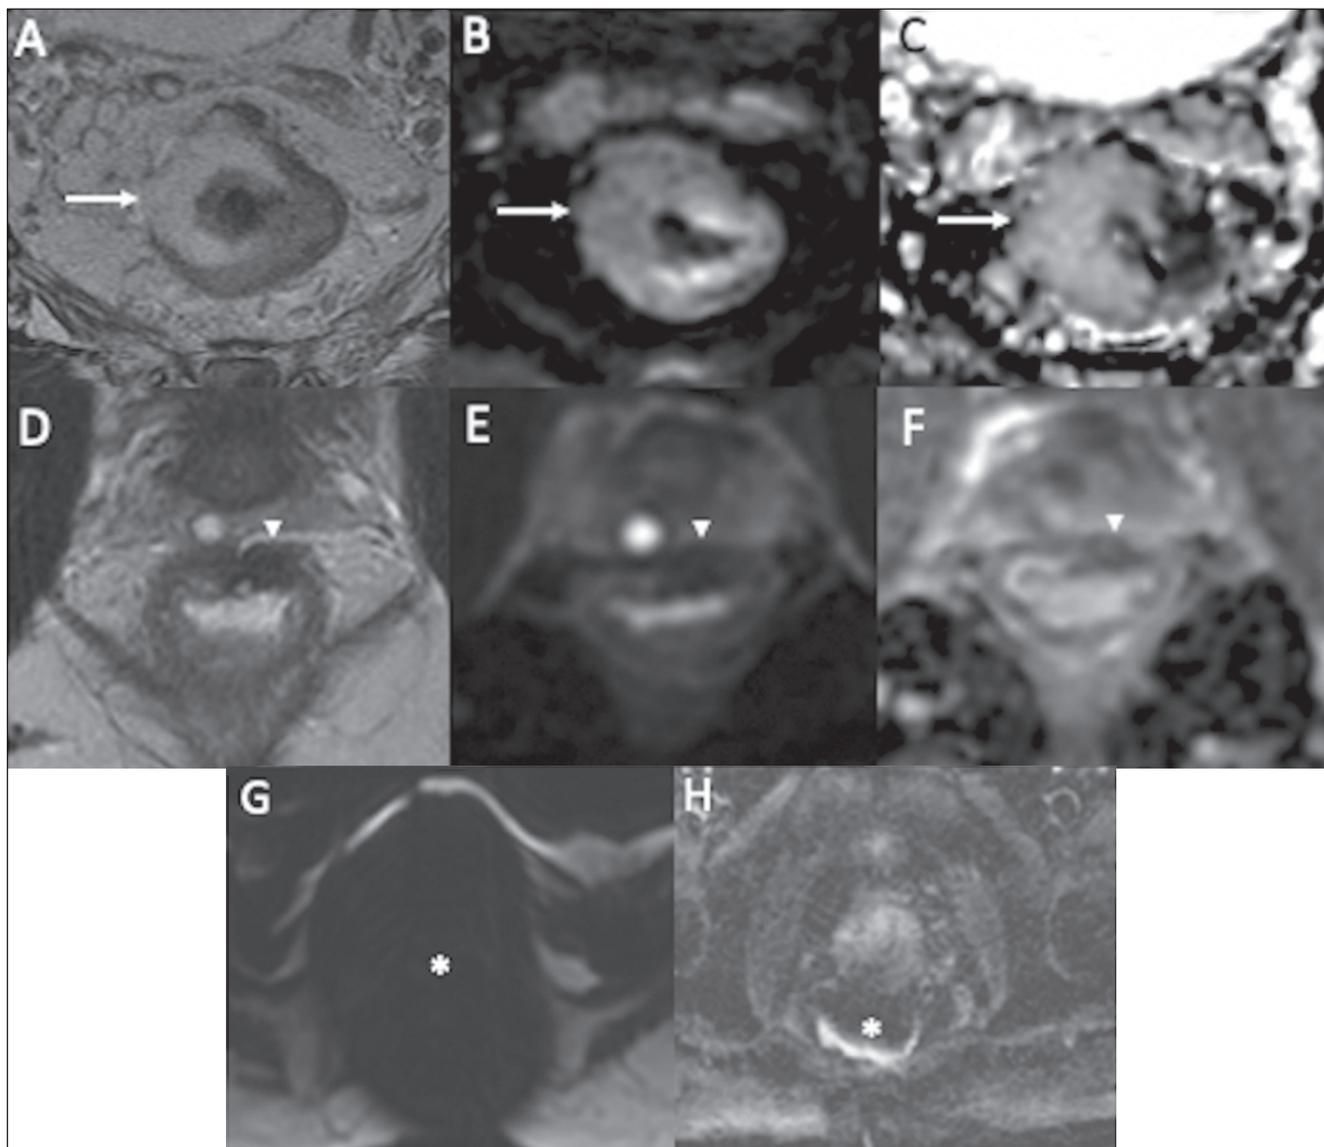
Examples of DWI artifacts. A–C: A T2 shine-through artifact (arrows) in a patient with a mucinous tumor showing high signal intensity on T2WI (A), DWI (B), and the ADC map (C). D–F: A T2 blackout artifact (arrowheads) identified by significant low signal intensity on T2WI (D), low signal intensity on DWI (E), and low signal intensity on the ADC map (F), representing fibrosis. G,H: Two additional examples of DWI artifacts (asterisks) due to surgical clips (G) and rectal air (H).
